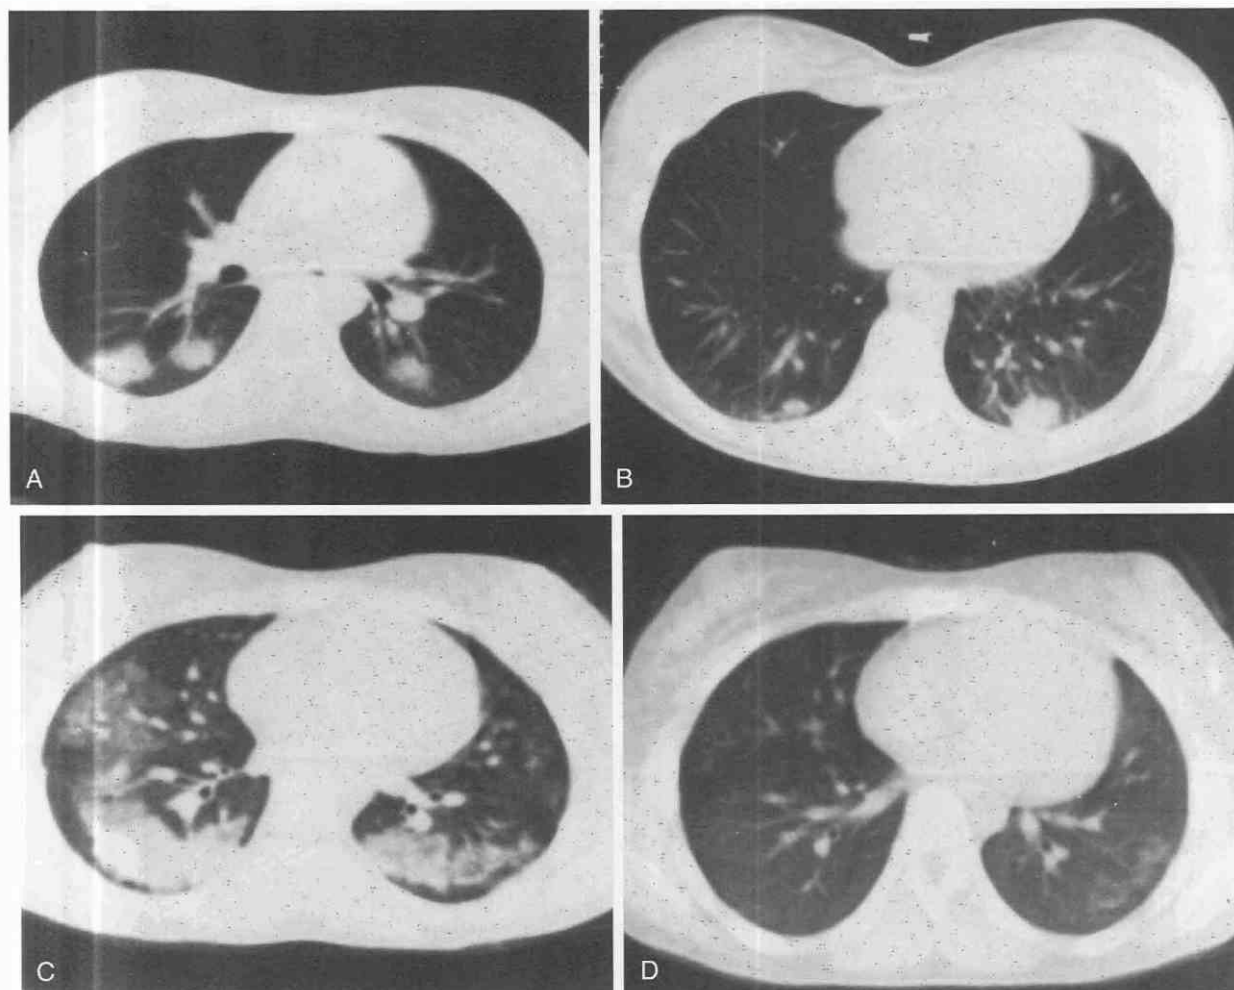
Bleomycin lung toxicity, CT features. A and B, CT shows nodular opacities, which may be mistaken for tumor recurrence or metastases but are actually caused by bleomycin toxicity, proven by biopsy. C, CT can be used to follow the progression or resolution of pulmonary toxicity. In this case, the nodular opacities progressed to larger areas of confluence. D, After discontinuation of the drug, a follow-up CT scan shows nearly complete resolution of the pulmonary lesions.
